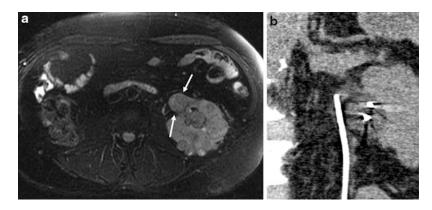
Role of ureteral stent during cryoablation. 65-year-old male with multifocal RCC and prior nephrectomy. (a) Axial T2-weighted MRI shows numerous masses in the solitary left kidney, including a 2.8-cm mass medially (*arrows*); (b) coronal CT image obtained
